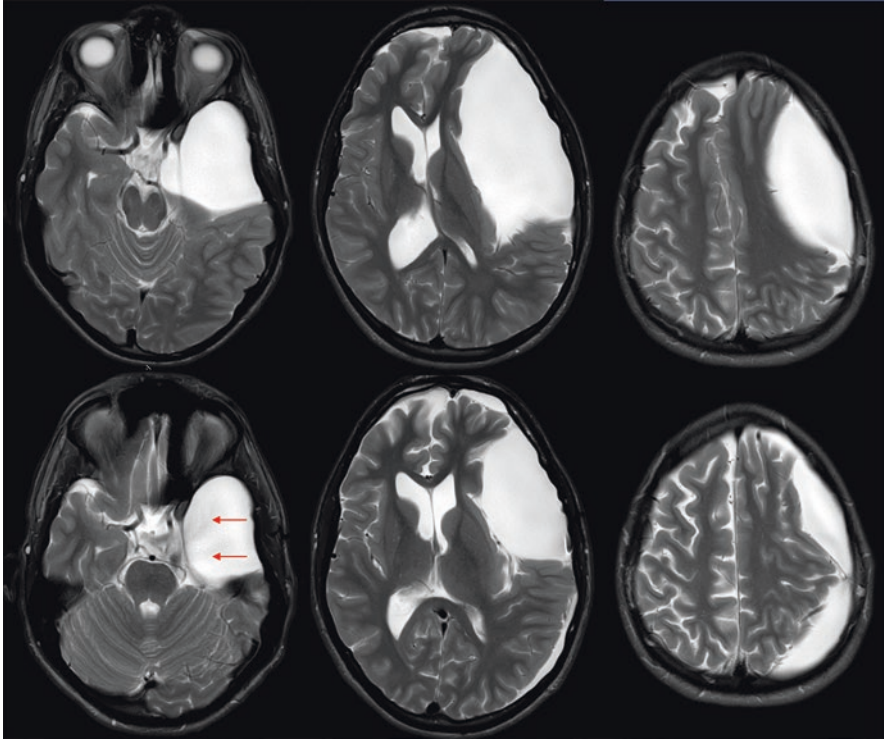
Axial T2-weighted MR images pre- (upper row) and post-op (lower row) of a Galassi type III AC, which displaces the optic nerve and chiasm to the right side. After microsurgical fenestration of the AC, a flow void through the fenestration can be detected (arrows), and the medial cyst wall is no longer herniating over the tentorial edge. The gyri of the frontal and parietal lobes are no longer compressed, but a subdural fluid collection can be seen
